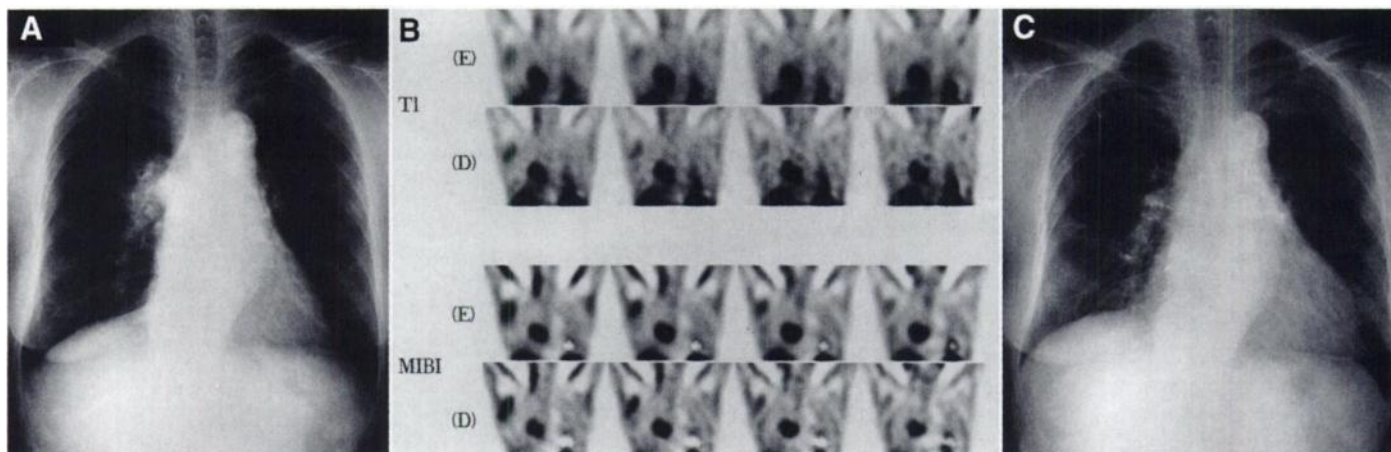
Radiologic findings in Patient 1. (A) Chest x-ray showing an abnormal shadow at the right hilum before chemotherapy. (B) Coronal SPECT images of both ^{201}Tl -chloride and $^{99\text{m}}\text{Tc}$ -MIBI SPECT demonstrate an abnormal accumulation corresponding to the lesion. E = early image; D = delayed image. (C) Chest x-ray showing no tumor after chemotherapy.
